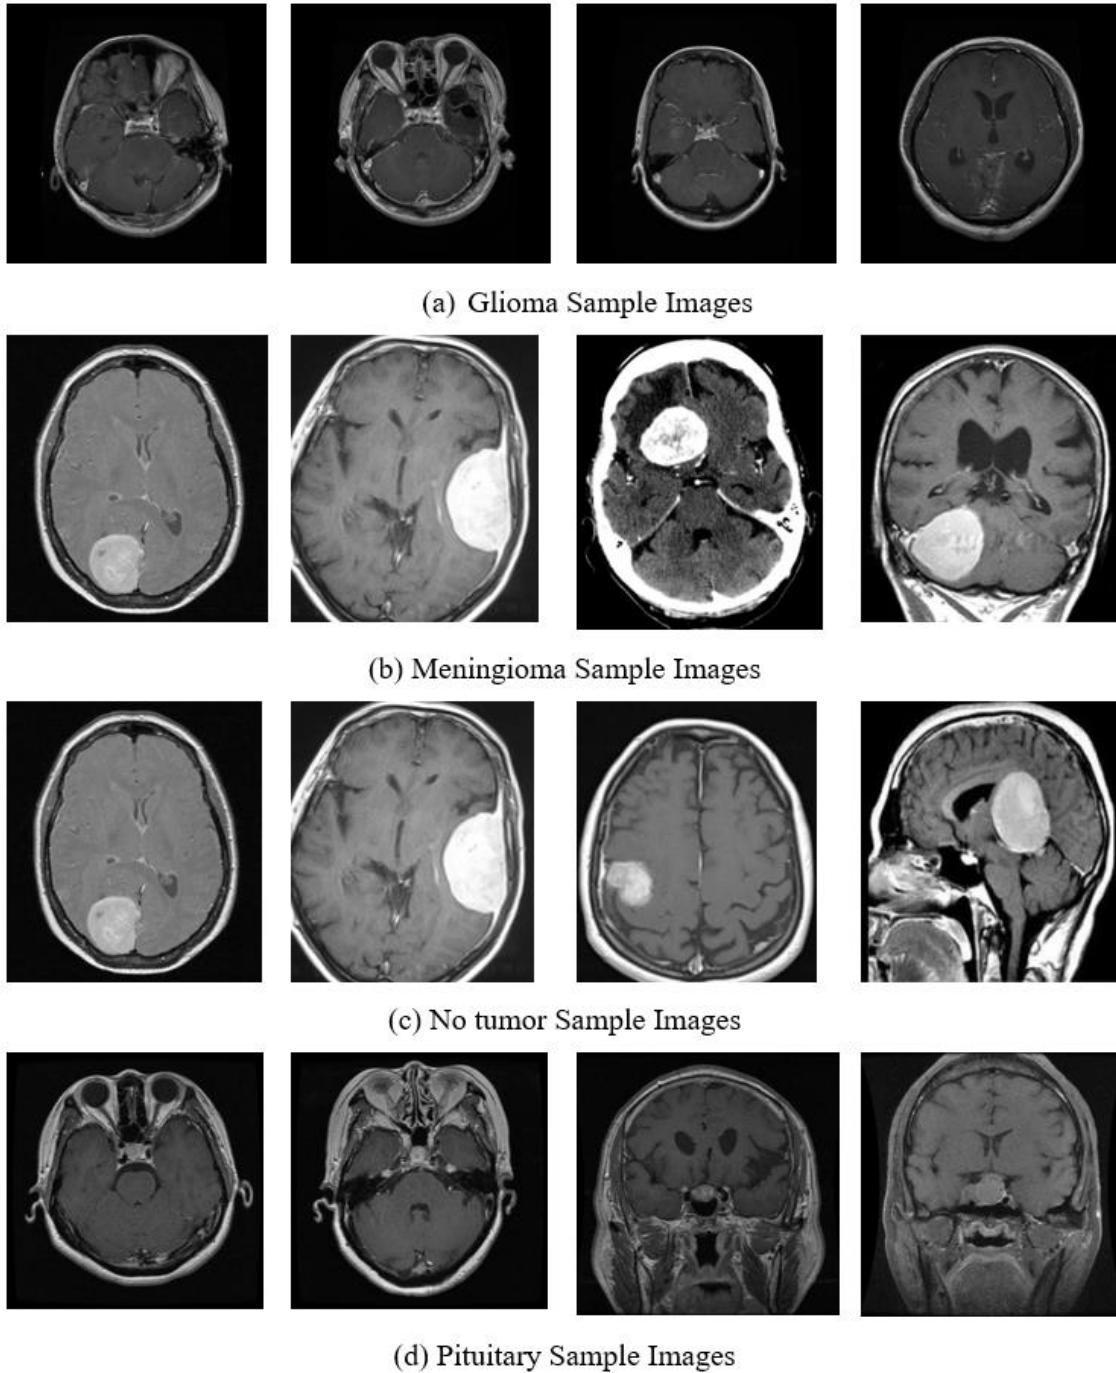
Sample Brain MRI Images.
